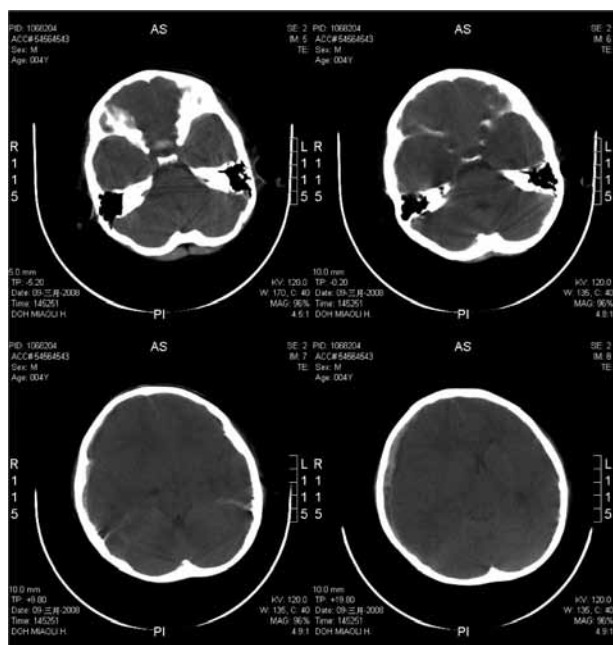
Initial brain CT without contrast showed SDH at right parietal lobe, SAH at right parieto-frontal lobe.
